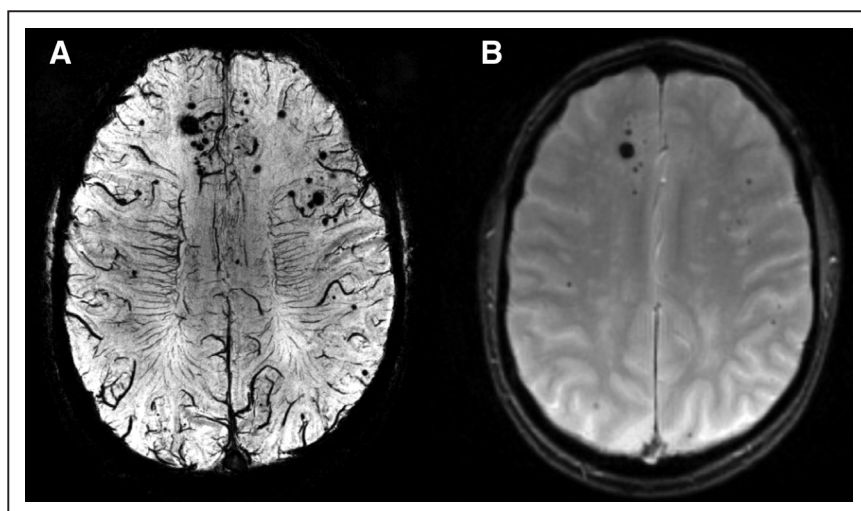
Impact of scanner/parameters on microbleed detection. Optimized susceptibility-weighted imaging obtained in Ultra-High Field (7T) magnetic resonance imaging (MRI) scanner (A) shows a much higher number of cortical microbleeds when compared with clinical-grade MRI (B) obtained on the same day in a patient with cerebral amyloid angiopathy.
